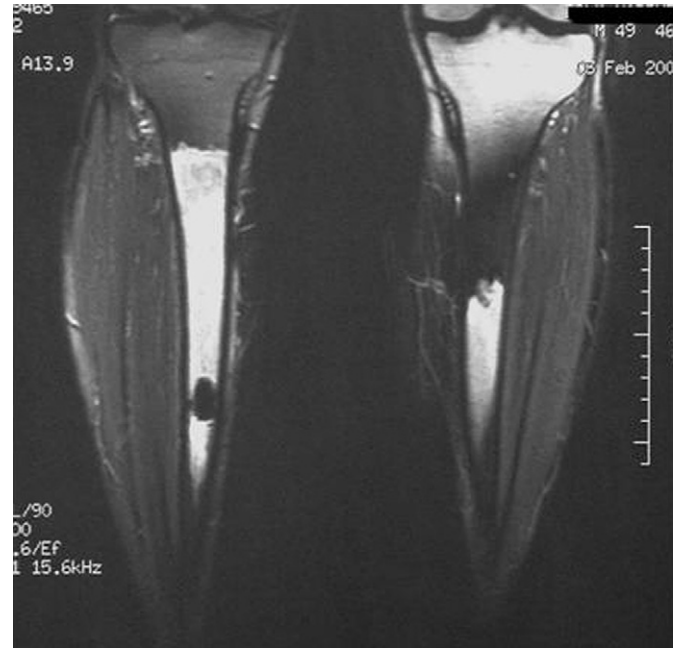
Coronal fat-saturated magnetic resonance image of the tibiae showing clear demarcation of the tumour. The initial biopsy site can be appreciated just below the midshaft of the right tibia.
